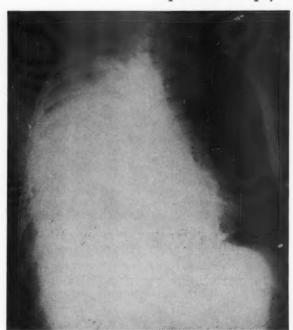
Case 39. Chest x-ray showing a massive right pleural effusion.
